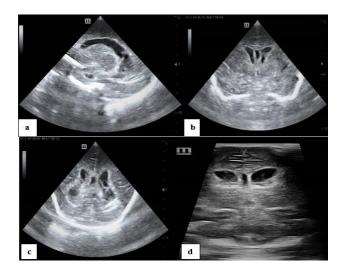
Ultrasound cranium (a) parasagittal view showing irregular ventricular margin and intraventricular strands; (b) coronal view at the level of 3rd ventricle; (c) coronal view posterior view; (d) on day 3 of admission, coronal view showing dilated ventricles.
